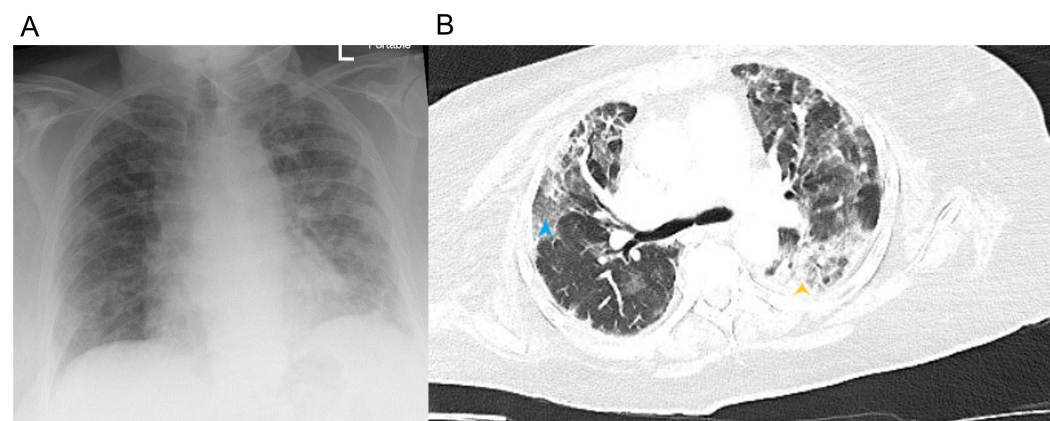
Examples of radiological changes in influenza pneumonia. (A) CXR shows ground glass and reticulonodular changes in a patient admitted with Influenza. (B) Corresponding CT showing ground glass (blue arrow) and consolidation (yellow arrow) in the same patient—source author. L, left.
